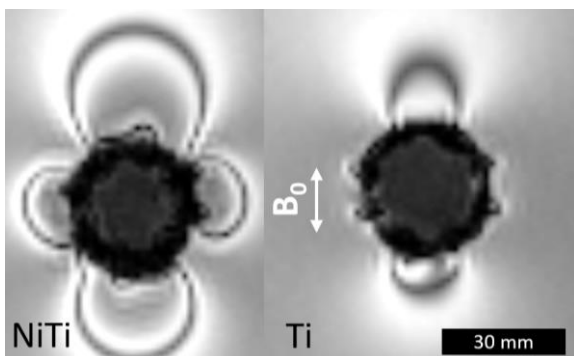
MRI images of NiTi and Ti structures.
